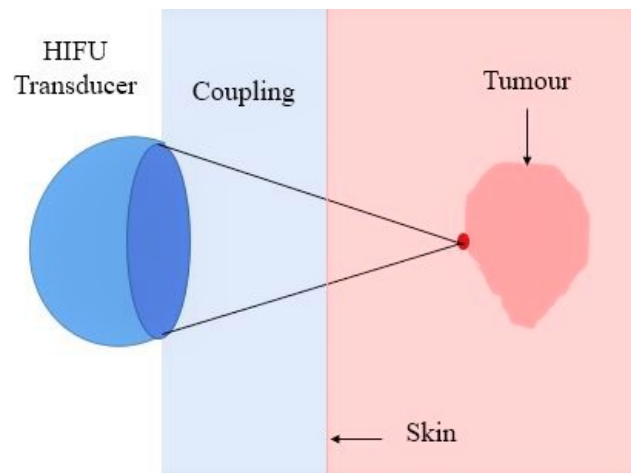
High intensity focused ultrasound
